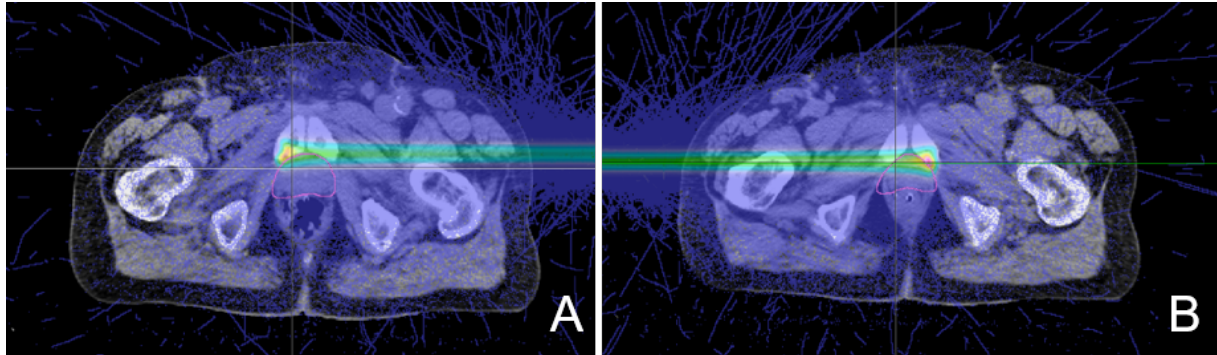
The CT scans with superimposed MC dose distributions of a good and a counter-indicated PB are shown on the left and right, respectively. The std values of the CT numbers for A and B are 96 and 236, respectively. (Tian et al. 2020)
